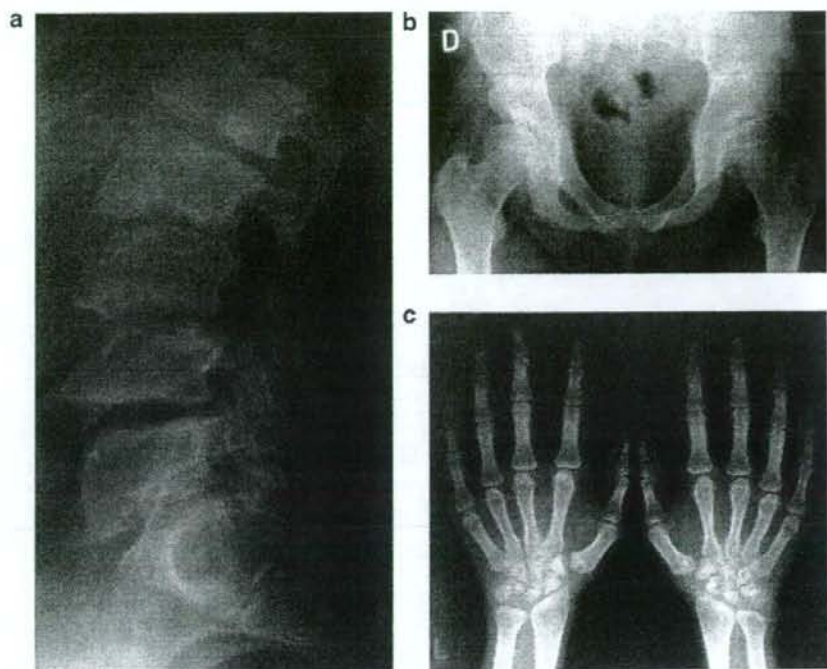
Bone radiograph. a: Vertebra (lateral view)—platyspondyly with ovoid vertebrae and anterior projection; and end-plates have irregular and rough surfaces. b: Hip joints—coxa valga, and dysplastic and wave-like acetabula. c: Hand—hypoplastic scaphoid and lunate bones; Madelung deformity of the radiocarpal articulation; and heads and bases of metacarpal bones spiky and mildly hypoplastic.
